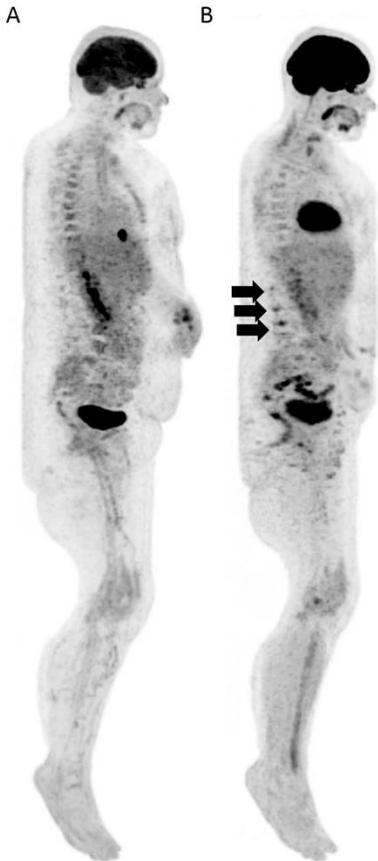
Total body FDG PET MIP images before (A) and after Nivolumab treatment (B). Increased uptake in bilateral hilar and mediastinal lymph nodes due to sarcoid-like reaction and gastritis (arrows) as well as multiple tumoral lesions (B) (details in the text).
